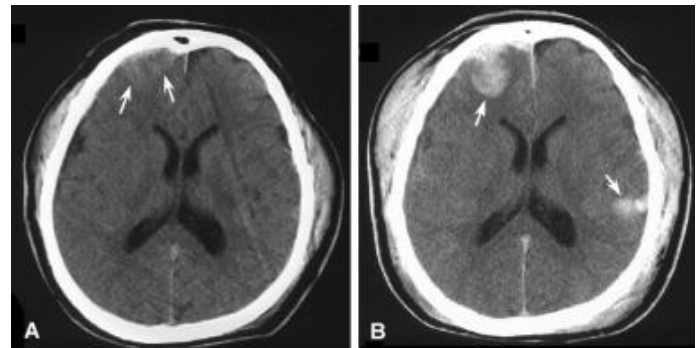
CT Brain showing head trauma with contusion
